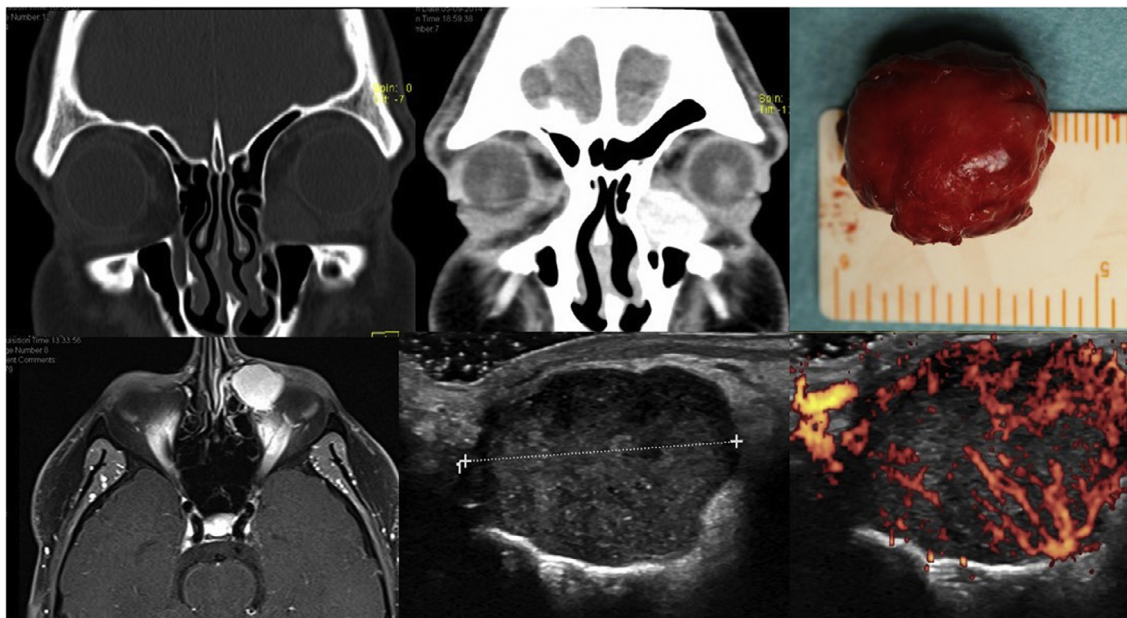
Top- CT and STF; Bottom: MRI and US.
